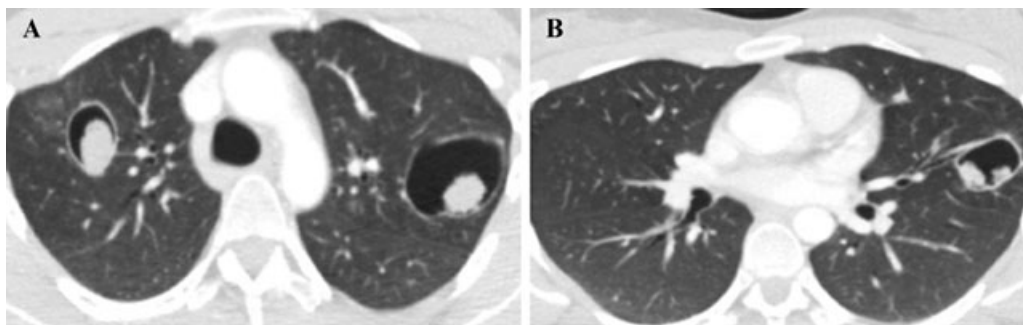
Patient 1. CT scan showing mild bronchiectasis with two thin-walled cavities bilaterally. In the right lung A is a section of the upper lobe, with B in the lower lobe showing the same cavity. Note that there are three separate aspergilloma in this cavity alone. Fungal balls measured 19 mm (left upper lobe, LUL), 28 mm (left upper lobe, LUL), 20, 18, and 9 mm (in same right upper lobe (RUL) cavity) and two others 20 mm and 23 mm.
